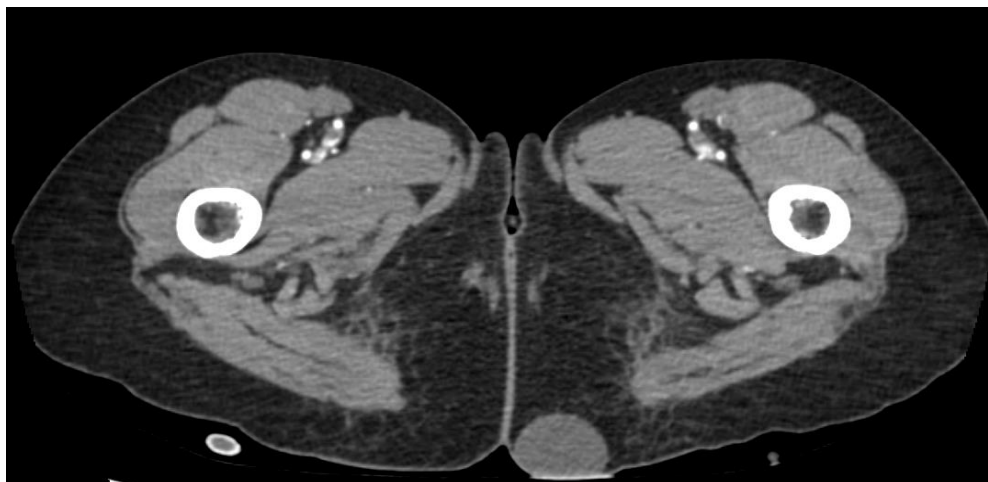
Contrast enhanced CT, axial view shows non-enhancing soft tissue density nodule seen on left of natal cleft.
